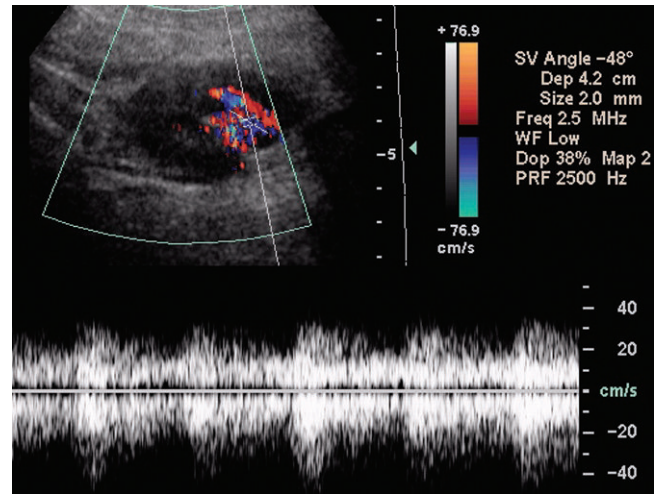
The transverse duplex and color Doppler sonogram of the right kidney shows an arterialized waveform in the vein draining the AVF.
